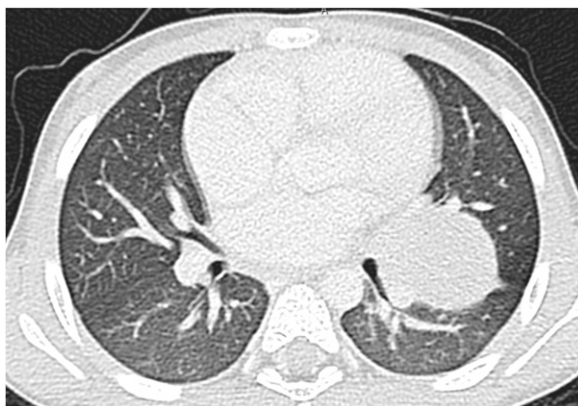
Computed tomographic scan of the chest showing a sharply margined, well-circumscribed round mass measuring approximately 3.7 × 3.8 × 3.3 cm in the anteroposterior, transverse, and cranial caudal dimensions, respectively, seen in the left hilum, centered at the bifurcation of the upper and lower bronchi. The mass appears solid and homogeneous in attenuation, without evidence of enhancement, necrosis, or internal calcifications.
